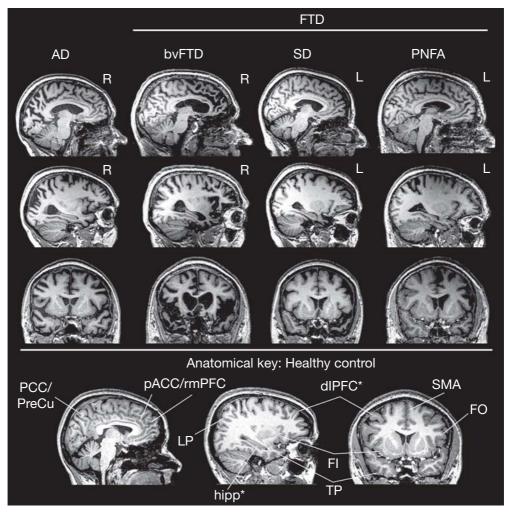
Practical approach to T1-weighted structural MRI in patients with FTD and AD. Evaluation of sagittal (adjacent to the midline and through the circular insular sulcus) and coronal (at the level of the temporal poles) slices can help differentiate AD from FTD subtypes. In AD, prominent atrophy in posterior cingulate/precuneus (PCC/preCu) and lateral parietal (LP) regions stands in contrast to sparing of pregenual ACC (pACC)/rmPFC and FI. BvFTD shows the opposite pattern, devastating ACC/rmPFC/FI and sparing PCC/preCu/LP. SD features marked often asymmetric temporal pole (TP) atrophy, and PNFA reflects dominant frontal operculum (FO) and supplementary motor area (SMA) degeneration. Comparable slices from a healthy control subject (bottom) provide an anatomical index. *Note that hippocampus (hipp) and dorsolateral prefrontal cortex (dIPFC) atrophy often fail to differentiate AD from FTD syndromes, especially in early age-at-onset patients. In the coronal images, the right side of the image corresponds to the left side of the brain.
